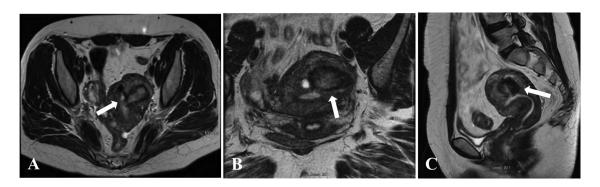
T2 MRI of abdomen and pelvis demonstrating approximately 6 months postuterine fibroid embolization. The fibroid remnant (white arrow) is seen in a transmural location projecting into the endometrial cavity: coronal (A), axial (B), and sagittal (C) views.
